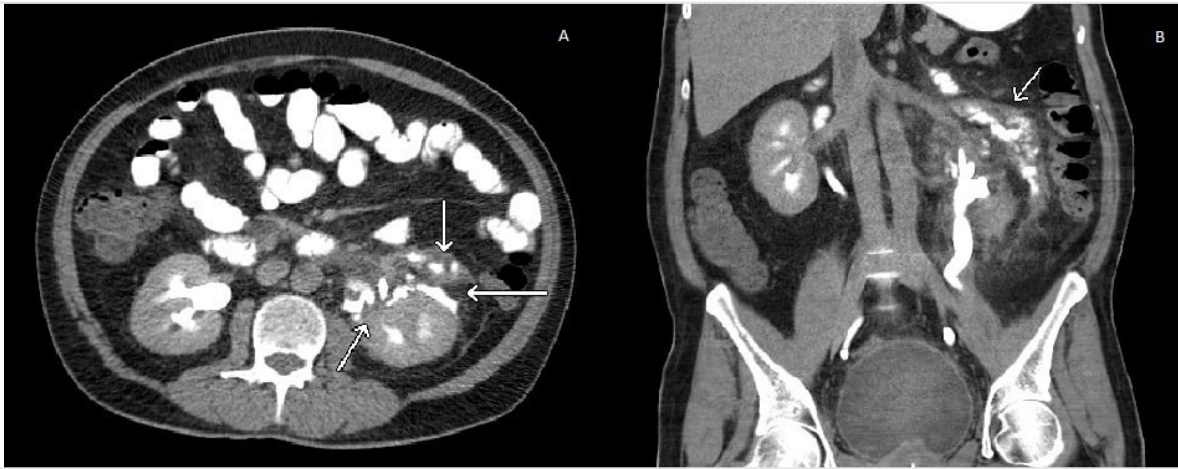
Free fluid around the kidney seen at CT-urography scan on coronal and axial views
